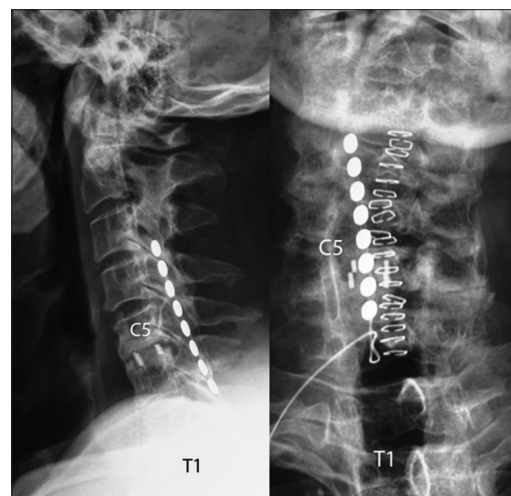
Postoperative cervical spine X-ray (anterior-posterior and lateral) after the placement of the subdural spinal cord stimulator at levels C3–C4 to C5–C6, showing also the polyetheretherketone at C5–C6 level.
